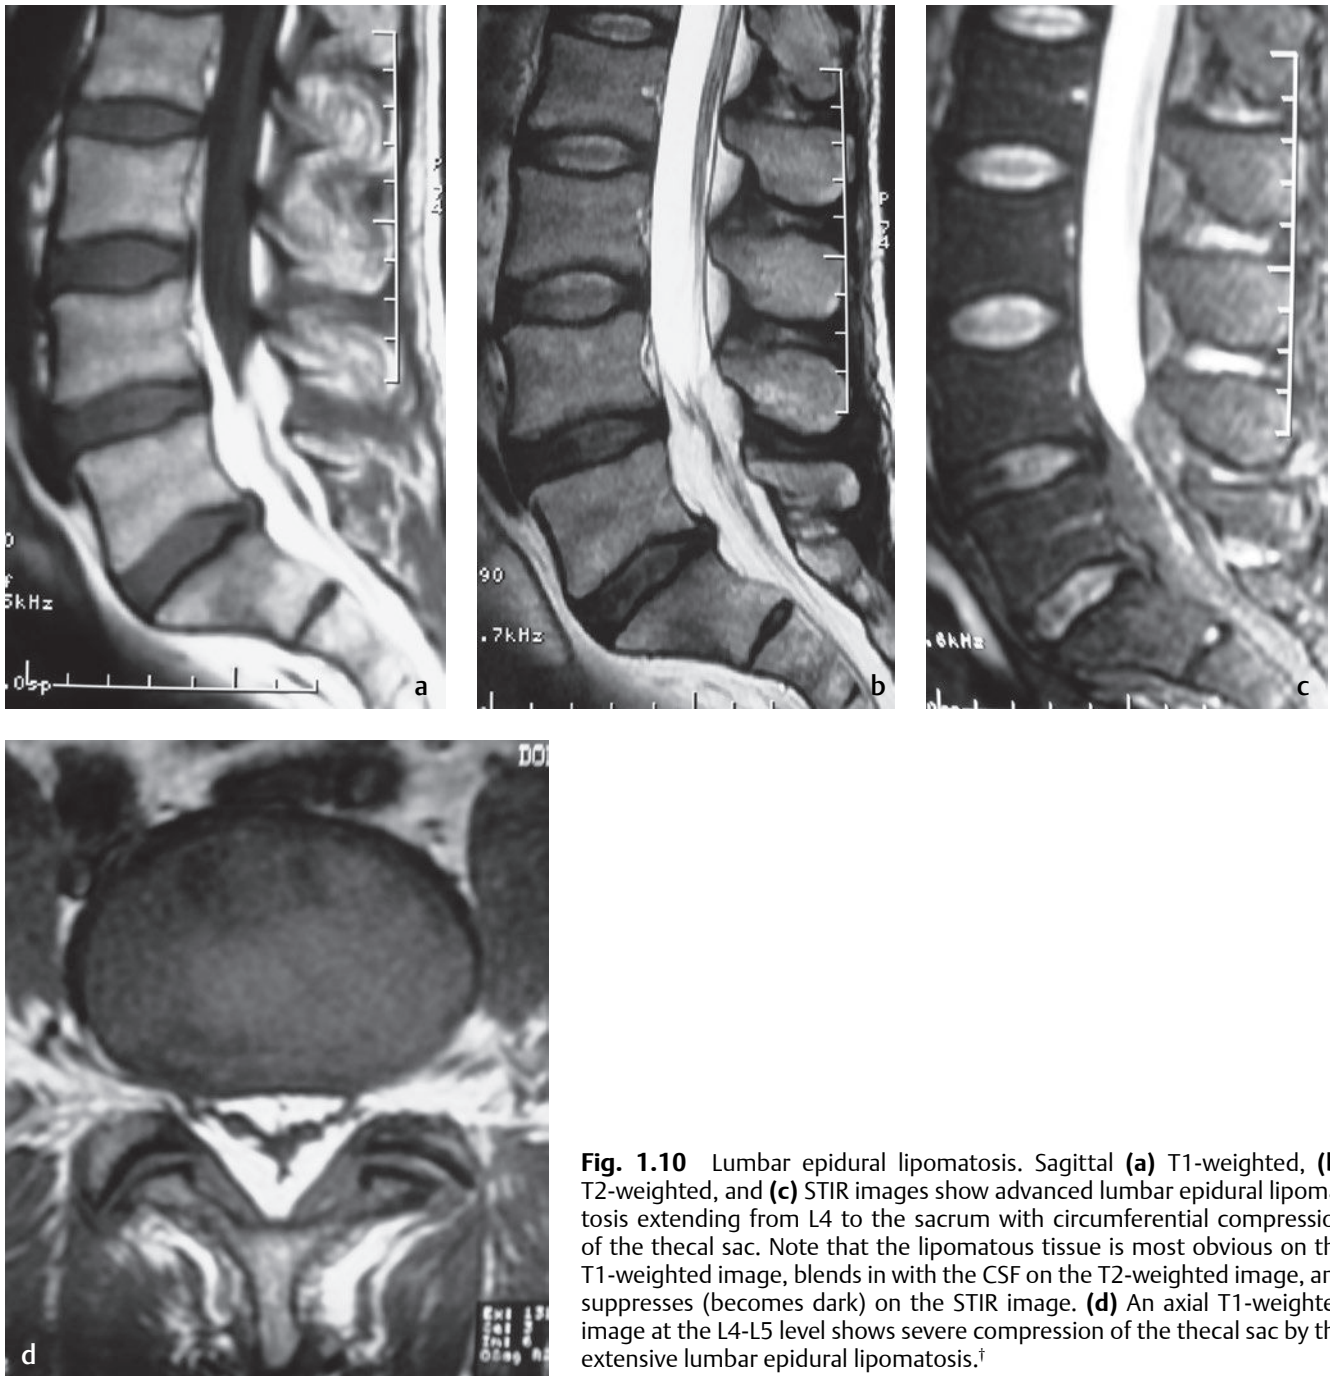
Lumbar epidural lipomatosis. Sagittal (a) T1-weighted, (b) T2-weighted, and (c) STIR images show advanced lumbar epidural lipomatosis extending from L4 to the sacrum with circumferential compression of the thecal sac. Note that the lipomatous tissue is most obvious on the T1-weighted image, blends in with the CSF on the T2-weighted image, and suppresses (becomes dark) on the STIR image. (d) An axial T1-weighted image at the L4-L5 level shows severe compression of the thecal sac by the extensive lumbar epidural lipomatosis.[†]
